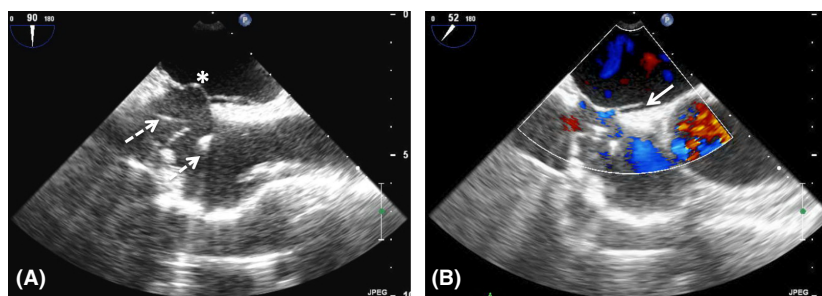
Transesophageal echocardiography of the bicaval view in 2 dimensions (A) and using color doppler (B), showing a mobile interatrial septum (asterisk) with a patent foramen ovale (solid arrow). Pacemaker leads are shown with dashed arrows.
